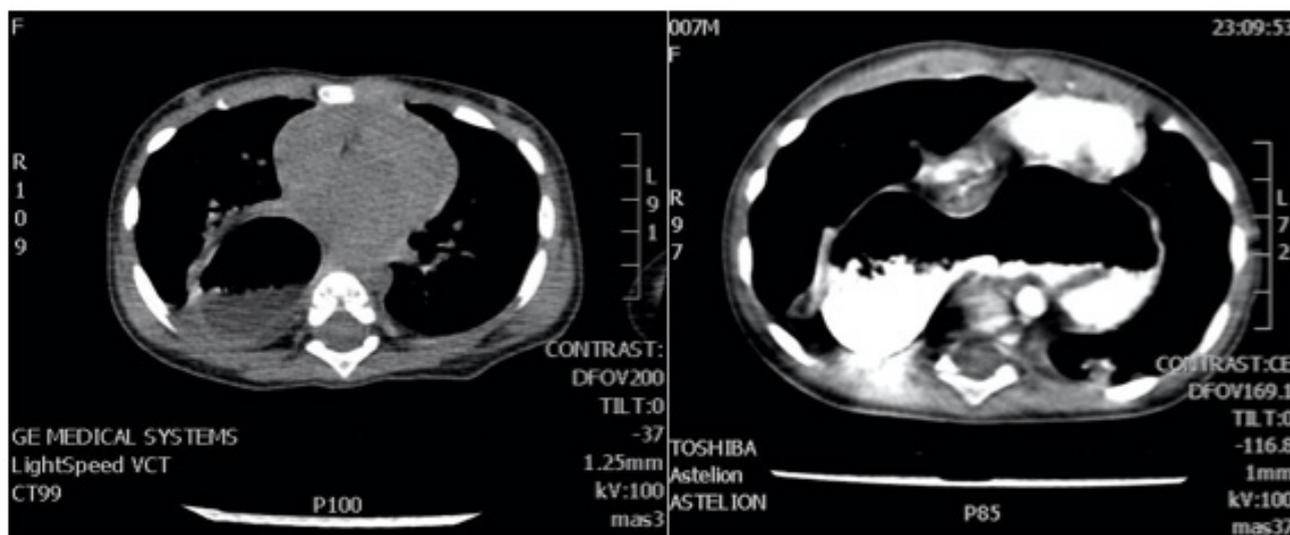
CT finding - stomach presence in the chest was suspected
